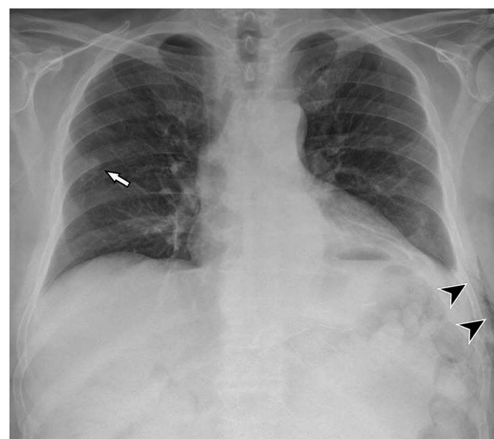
Normal chest X-ray after the removal of left pulmonary drainage. Presence of a small amount of subcutaneous emphysema (black arrowheads) and previously confirmed right upper lobe nodule (white arrow).
